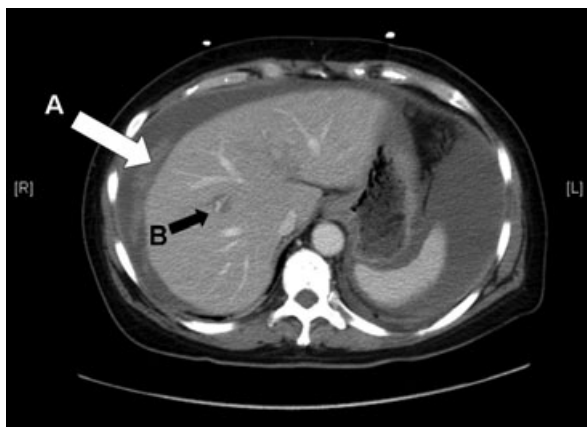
Computed tomography scan of the liver after islet infusion and recurrence of drop in hemoglobin. Arrow A: Area of extravasation of iodine contrast agent indicating arterial bleeding. Arrow B: Area of injury; the false aneurysm is not visualized.
